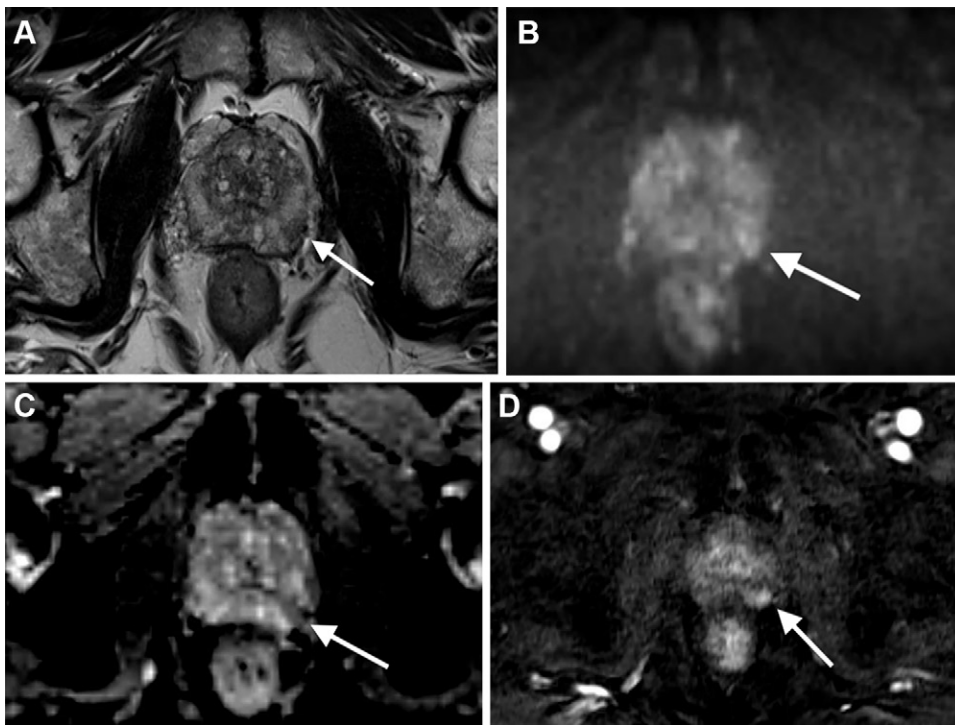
Multiparametric MRI (mpMRI) of the prostate prior to transrectal MRI-guided focused ultrasound (MRgFUS). mpMRI scans demonstrate a suspicious lesion (arrow) in the mid prostate left posterolateral peripheral zone measuring less than 15 mm that was (A) hypointense on the T2-weighted scan, (B) hyperintense on the diffusion-weighted scan, and (C) hypointense on the apparent diffusion coefficient scan, with (D) early enhancement on the dynamic contrast-enhanced sequence, consistent with a Prostate Imaging Reporting and Data System, or PI-RADS, category 4 lesion. No other suspicious lesions were seen in the prostate at mpMRI. No extraprostatic extension, neurovascular bundle invasion, or seminal vesicle involvement was seen. Staging imaging workup was negative for metastasis. MRI-guided biopsy demonstrated prostatic adenocarcinoma, grade group 3. The patient subsequently underwent MRgFUS.
